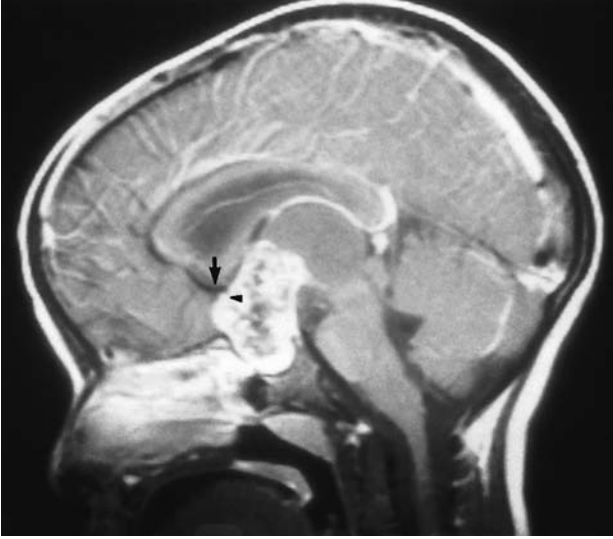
Midsagittal MRI showing a partially calcified craniopharyngioma with a large cyst occupying the third ventricle. Note that the anterior cerebral artery (*arrow*) and optic chiasm (*arrowhead*) are elevated (postfixed chiasm).
